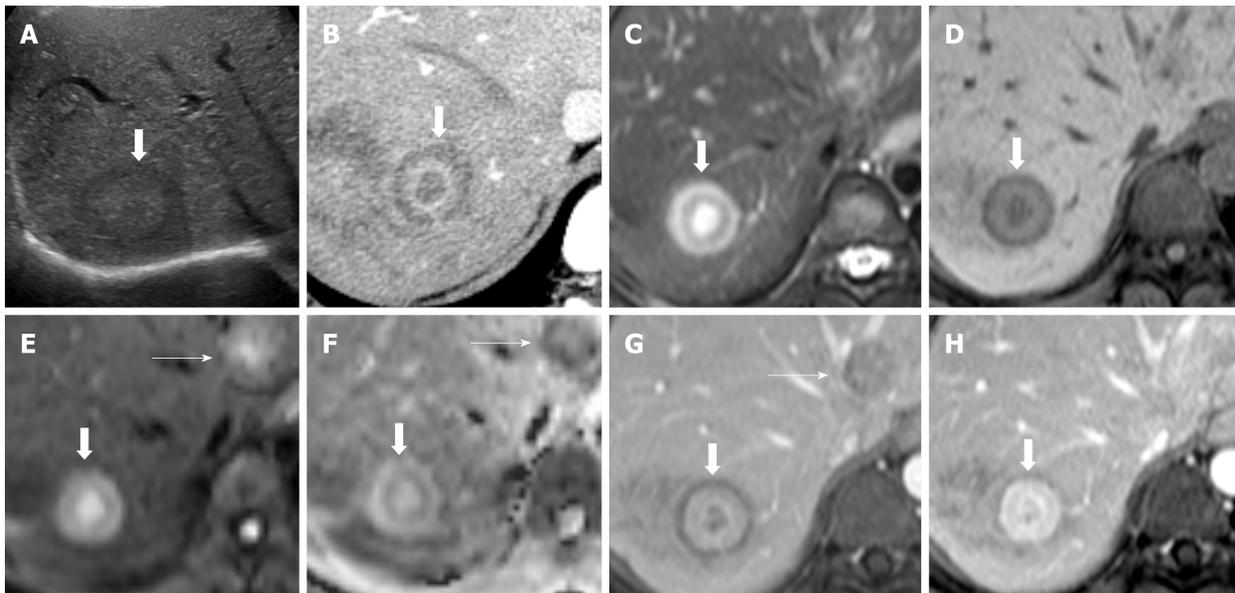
Hepatic hemangioepithelioma imaging feature. A: Transverse ultrasound of the right upper abdomen reveals a iso to mildly hypoechoic lesion (arrow) in the liver; B: Axial contrast enhanced CT image of the liver; C: Axial T2 weighted images (T2WI); D: Axial pre contrast T1 weighted images (T1WI); E: Axial diffusion weighted image (DWI); F: Apparent diffusion coefficient; G: Axial post contrast T1WI portovenous; and H: Axial post contrast T1WI venous magnetic resonance imaging (MRI) images. On T2WI, a target appearance consists of a core with high signal intensity (similar to fluid), a thin ring with low signal intensity, and a peripheral halo with slight hyperintense signal (thick arrows). On dynamic study, it consists of an hypodense/hypointense core, surrounded by a layer of enhancement and a thin peripheral hypodense/hypointense halo (thick arrows). Other hepatic hemangioepithelioma nodules are also noted (thin nodules). T2WI: T2 Weighted Images; T1WI: T1 weighted images; DWI: diffusion weighted image; MRI: Magnetic resonance imaging.
